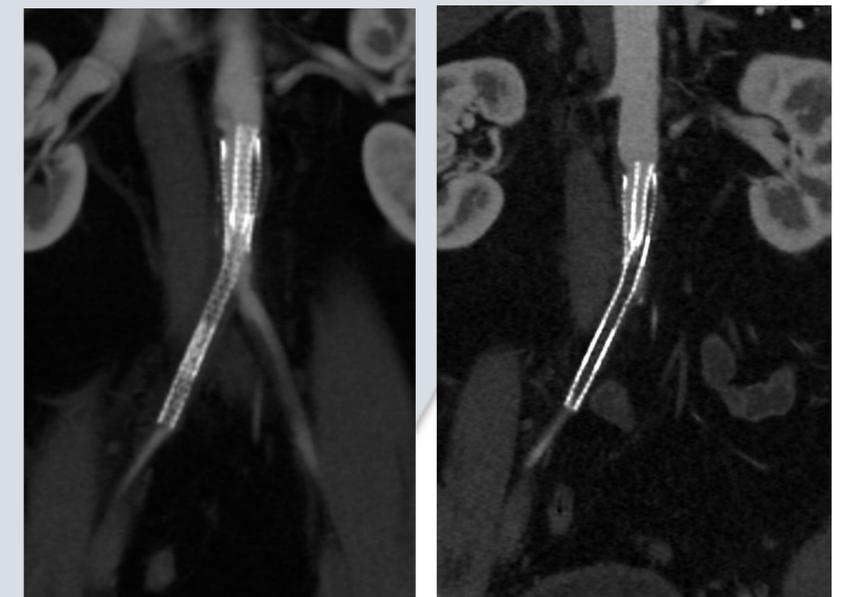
CT angiogram demonstrates occluded right CIA stent and proximally migrated left CIA stent
